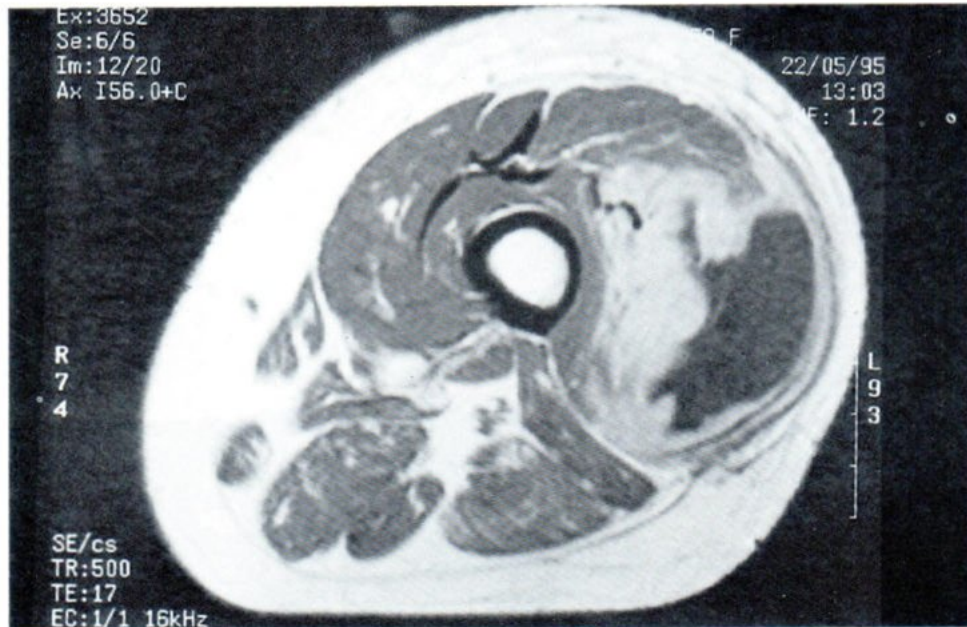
(c) Gadolinium enhanced axial image shows enhancement of the wall of the abscess and the adjacent muscle which corresponded to the areas of increase signal intensity in the T2-weighted image.
